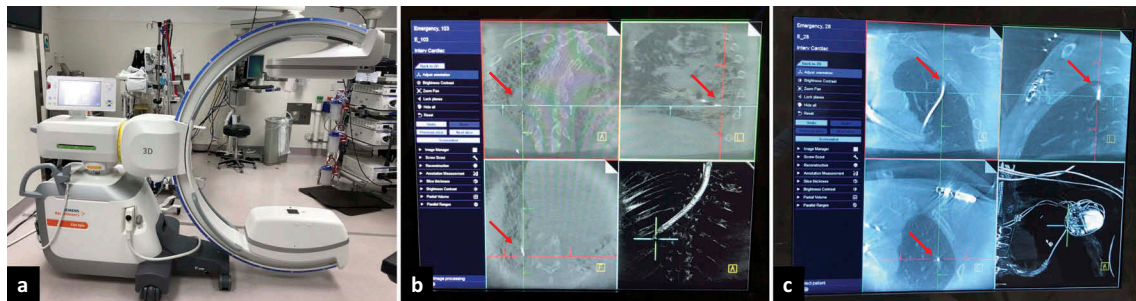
Fluoroscopy with three-dimensional image reconstruction. The Cios Spin mobile C-arm (Siemens Healthineers) acquires fluoroscopic images at a rapid frame-rate while performing an automated 180-degree rotation around a target (a). Tomographic image-reconstruction facilitates visualization of lesions (arrows) in three dimensions with image-quality similar to cone-beam CT but at a much lower radiation-dose (b, c). This technology shows promise in visualizing lesions that may be invisible or obscured on three-dimensional fluoroscopy – for example, this small upper-lobe nodule lying posterior to an implanted cardiac device on the standard posteroanterior view (c, arrow).
